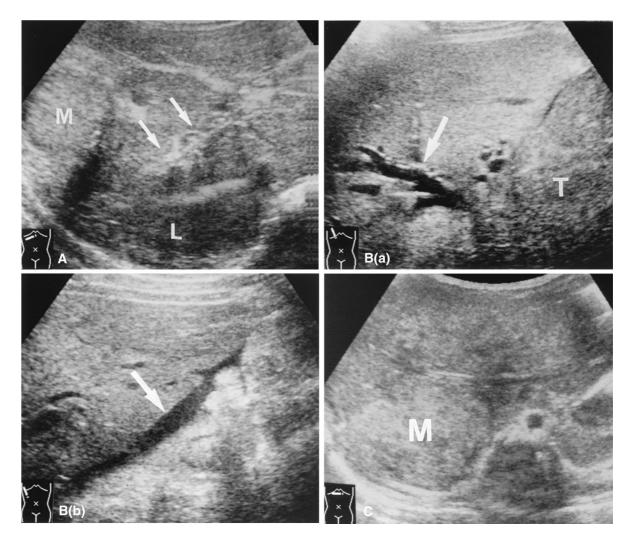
Representative sonograms of malignant tumors. A Hepatoblastoma: An echogenic mass (M) associated with portal tumor thrombus (*arrows*). L liver. B Hepatocellular carcinoma. B(a) HCC tumor nodule
